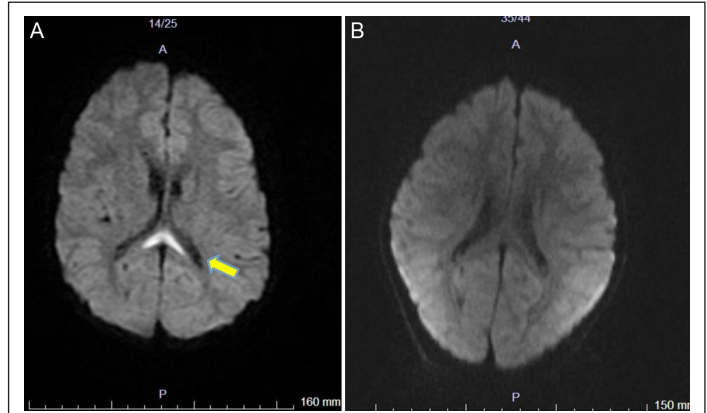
(A) Hyperintensity and diffusion restriction of the corpus callosum splenium in brain diffusion-weighted magnetic resonance imaging. (B) Normal appearance of corpus callosum splenium in brain diffusion-weighted magnetic resonance imaging.
